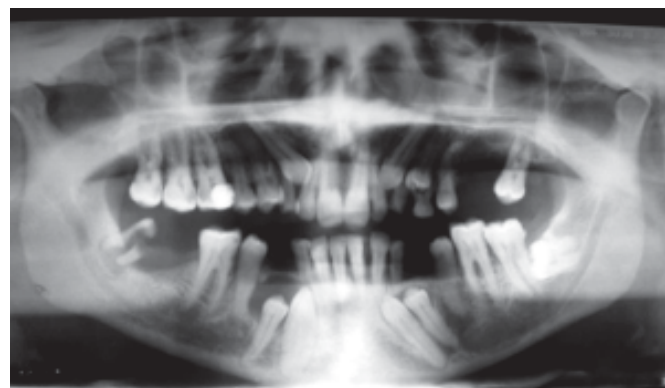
A panoramic radiograph of 45 years male patient shows multiple impacted permanent teeth number 13, 23, 24, 33, 34, 43 and 44 with well defined unilocular radiolucency surrounding the crown on impacted teeth # 43 and 44.
